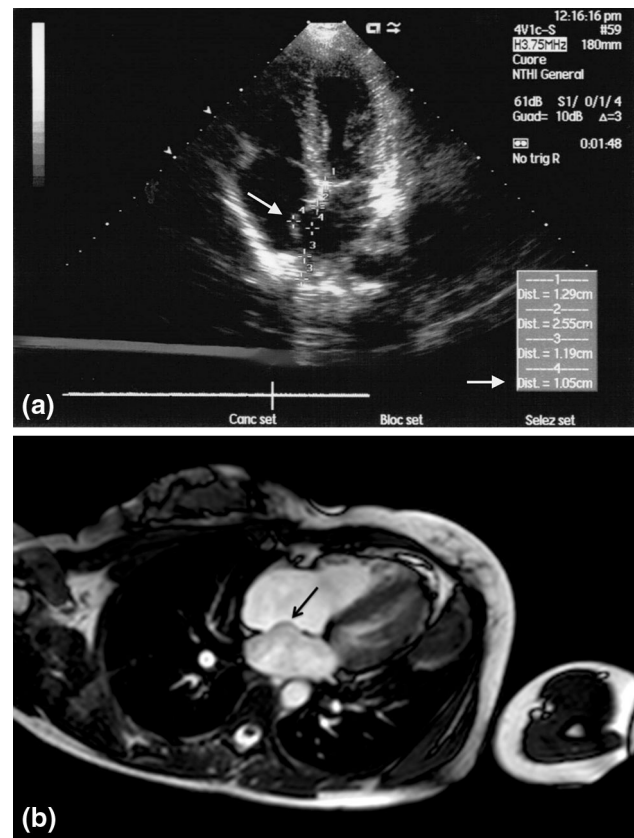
a Echocardiography image showing the thin, floppy, hypermobile inter-atrial septum aneurysm that protrudes by 1.05 cm in the right atrium during the cardiac cycle (*arrows*). b Four-chamber balanced TFE cardiac MR image confirming the presence of the inter-atrial septal aneurysm (*arrow*)
